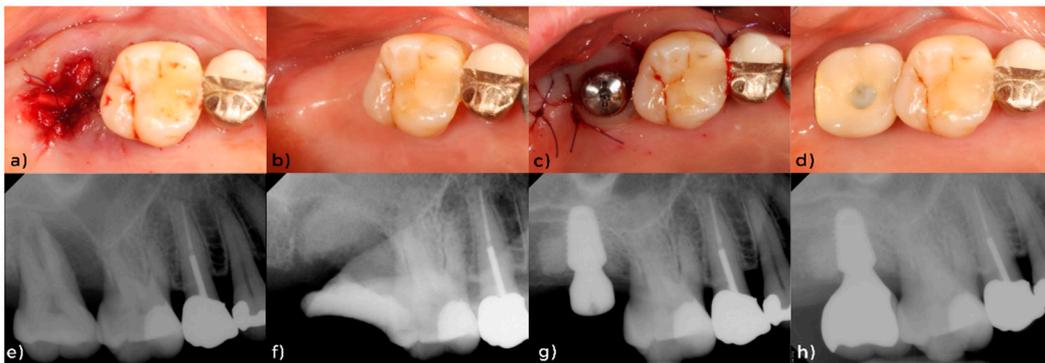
Clinical photos and peri-apical radiographs of Case II. Clinical photos of (a) after alveolar ridge preservation (ARP), (b) two years after ARP, (c) after implantation, (d) after prosthesis delivery. Peri-apical radiographs of (e) before extraction, (f) after ARP, (g) after implantation, (h) after prosthesis delivery.
